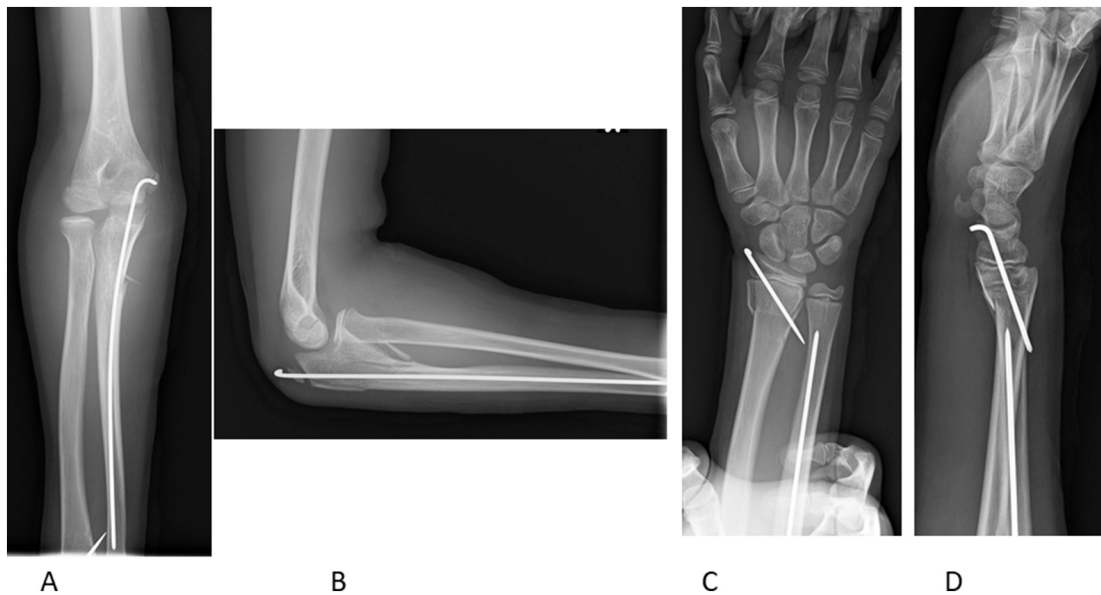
Postoperative radiographs of the right elbow (A: frontal view, B: lateral view) and the right wrist (C: frontal view, D: lateral view).
